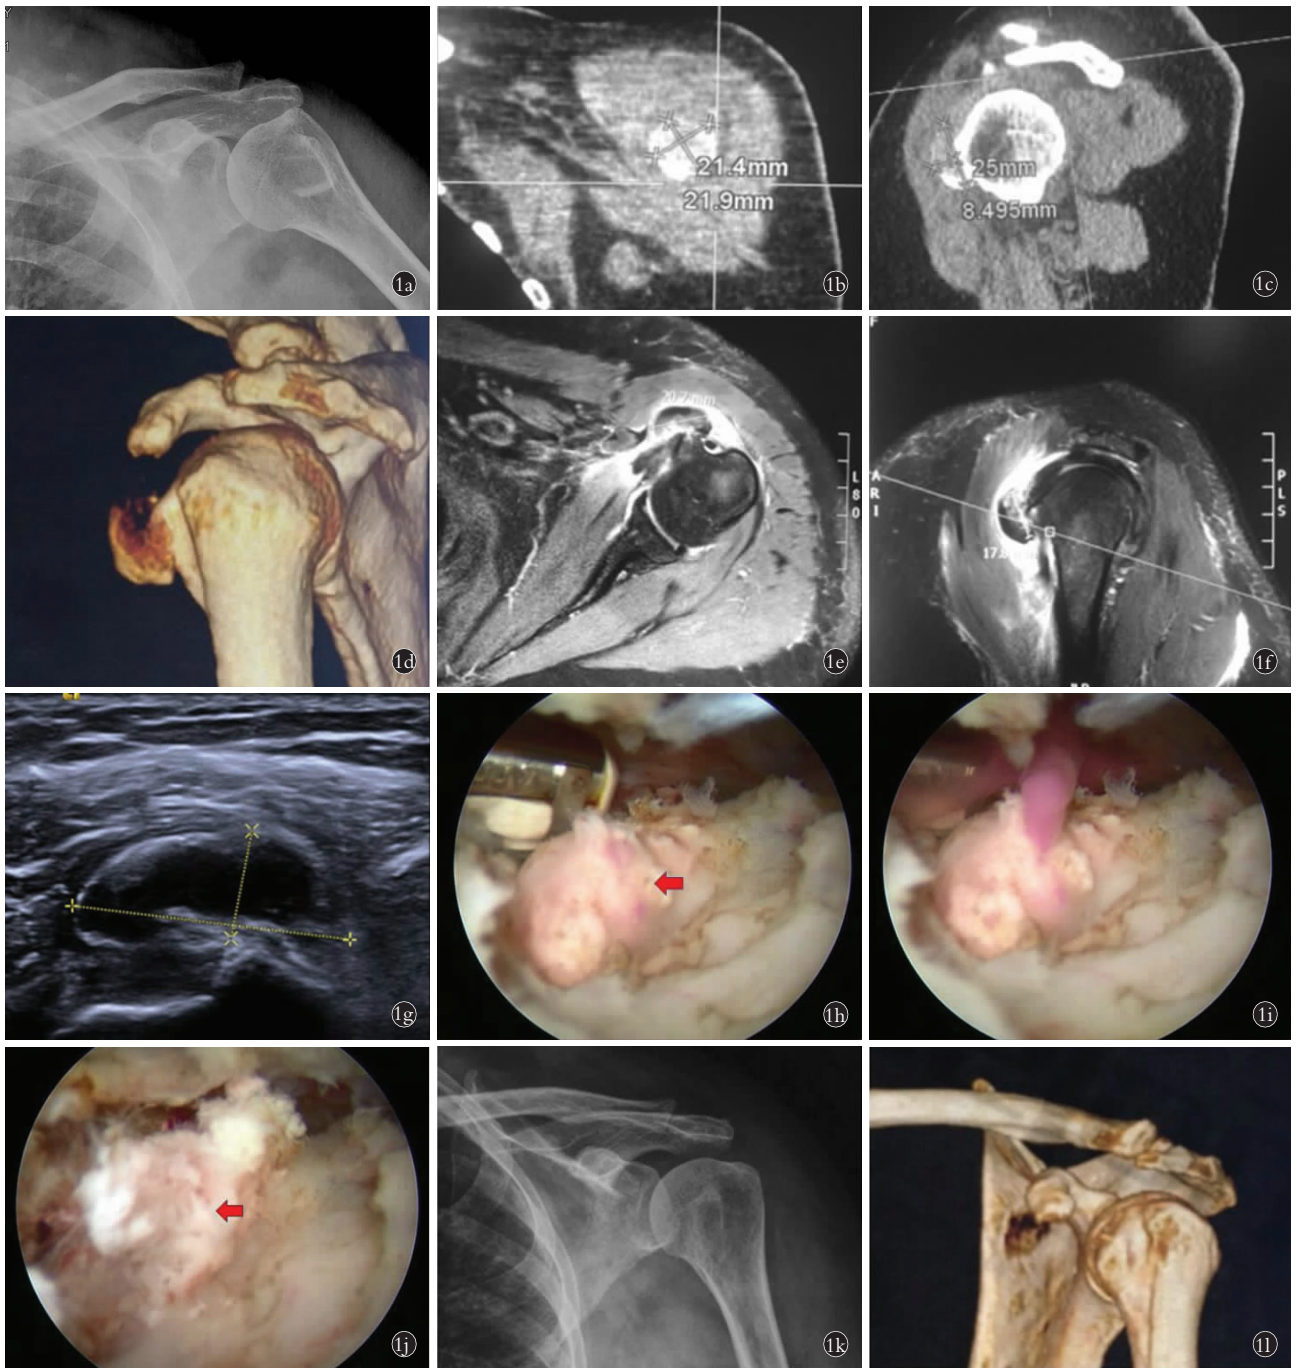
患者,女,64 岁,左肩部疼痛伴活动受限 6 个月 1a. 术前 X 线片示肱骨头前方不均匀高密度影 1b. CT 片测量钙化灶表面大小 21.4 mm×21.9 mm 1c. CT 片测量钙化灶厚度为 8.5 mm 1d. CT 三维重建显示肱骨前方可见圆形片状不均匀钙化影 1e. MRI 可见肩胛下肌止点前方不均匀圆形低信号影,长 20.7 mm 1f. MRI 可见肩胛下肌止点前方不均匀圆形低信号影,宽 17.6 mm 1g. 超声提示肩胛下肌囊性钙化影,长 24.5 mm,宽 9.6 mm 1h. 红色箭头所指为肩胛下肌滑膜侧红色钙化灶 1i. 钙化灶内部红色血性内容物流出 1j. 箭头所指为钙化灶囊壁 1k. 术后复查 X 线未见钙化灶 1l. 术后复查 CT 三维重建,小结节前方钙化灶彻底清除
